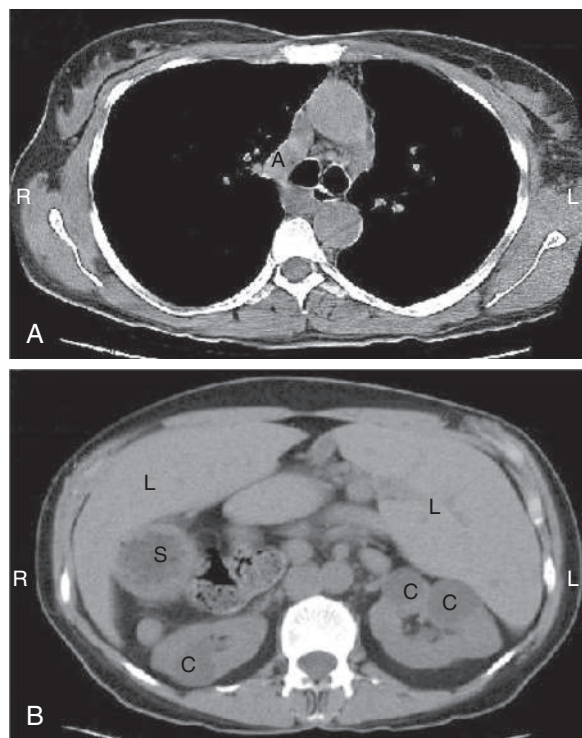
Right isomerism with asplenia. Noncontrast-enhanced CT scan of a female with primary ciliary dyskinesia demonstrates features of right isomerism with asplenia. A, Large azygous vein arch is noted, which compensates for the inferior vena cava interruption. B, CT scan through the upper abdomen demonstrates midline liver (L), dextrogastric (S), and absent spleen. Bilateral renal cysts (C) are also noted. (From Chmura K, Chan ED, Noone PG, Zariwala M, Winn RA, Knowles MR, Iseman MD, Gardner EM. A middle-aged woman with recurrent respiratory infections. *Respiration*. 2005;72(4):427–430.)
